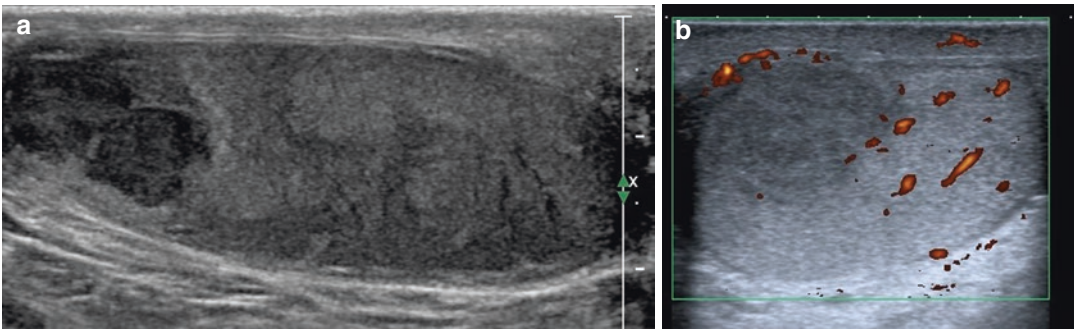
(a) US evaluation shows an intact albuginea and the presence of a subalbuginea haematomas. (b) Power Doppler investigation reveals a large portion of ischaemic parenchyma
